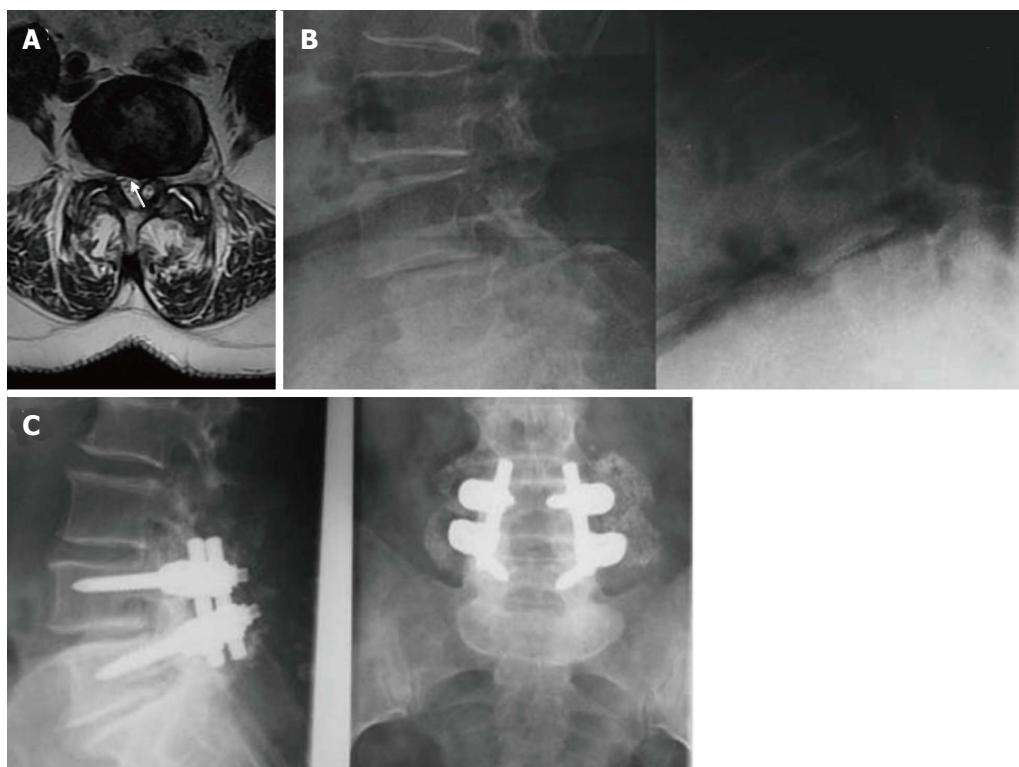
Case 2, Table 1. Preoperative axial T2-weighted MR image (A) showing a dehydrated and hypointense disk with a hyperintense cystic formation at right L4-L5 level (arrow). The cyst appeared to be of the internal or flavum type (see text for the classification). Sagittal dynamic images (B) 12 mo after the first surgical treatment showed an unstable olisthesis at L4-L5 level. Standard X-rays performed 1 year after surgical stabilization (C) showed the instrumentation to be well-positioned with an optimal profile and fusion at L4-L5.
